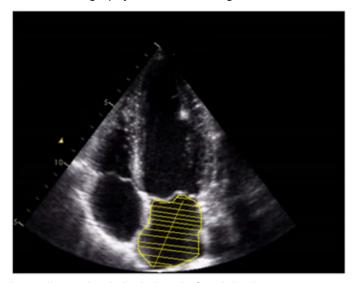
Bidimensional echocardiography. Apical view. Left atrial volume measurement using the biplane modified Simpson method. Four-chamber view.
